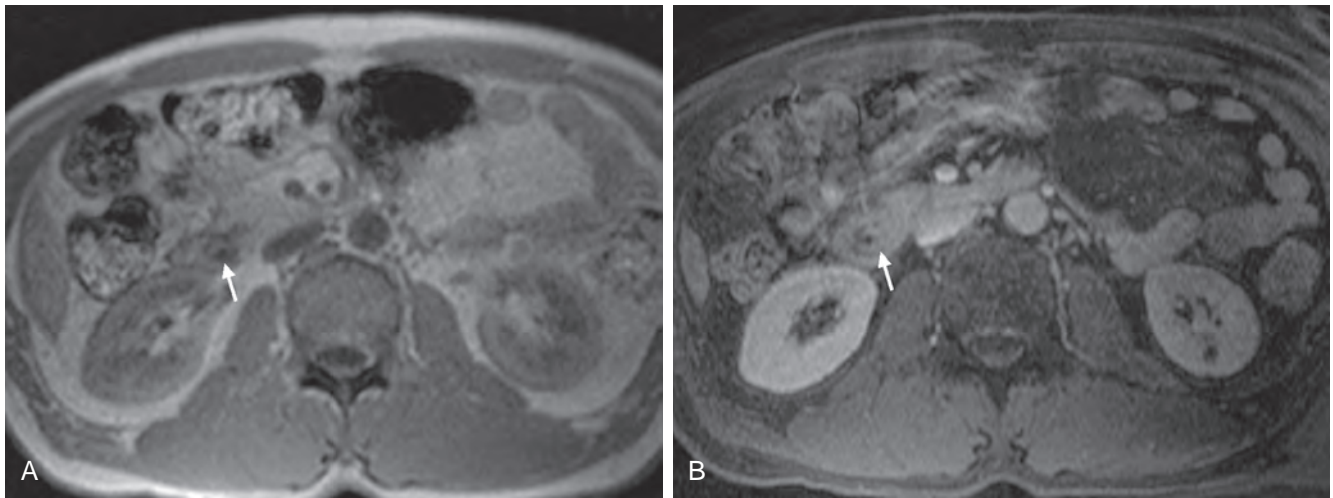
Ampullary cancer: MR findings. A. T1-weighted image shows a hypointense ampullary tumor (arrow). B. Postgadolinium fat-suppressed image demonstrates a thin rim of enhancement (arrow) along the periphery of the tumor.
